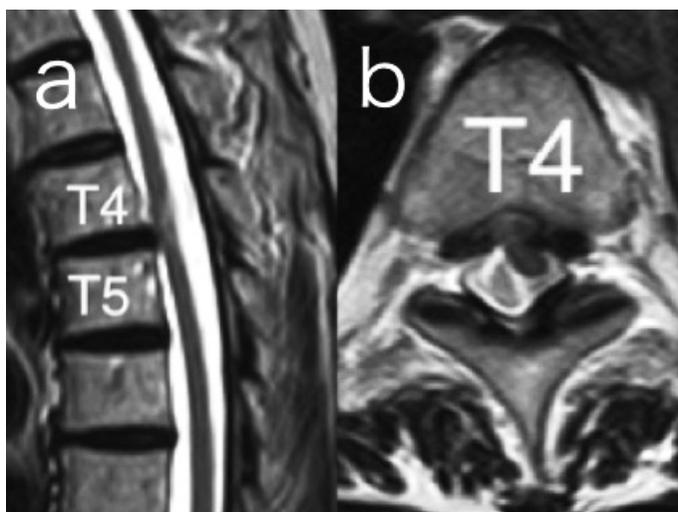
(a and b) Preoperative MR (1.5-T) T2-weighted image
